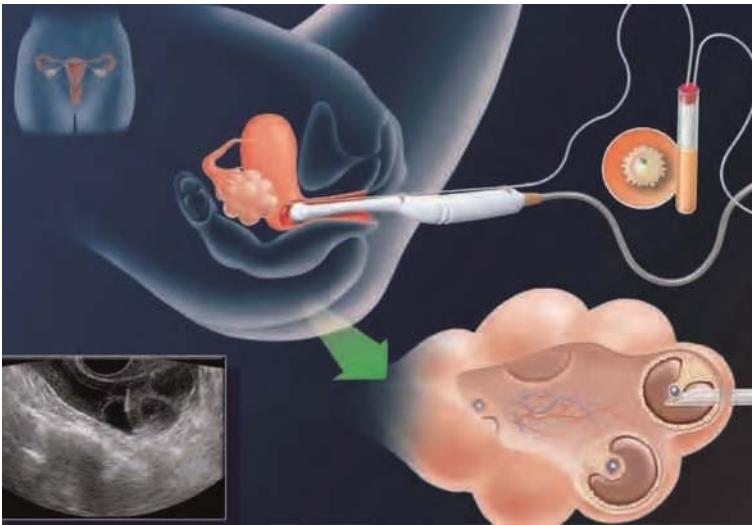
Ultrasound appearance of ovaries following stimulation with follicle stimulating hormone (FSH).
